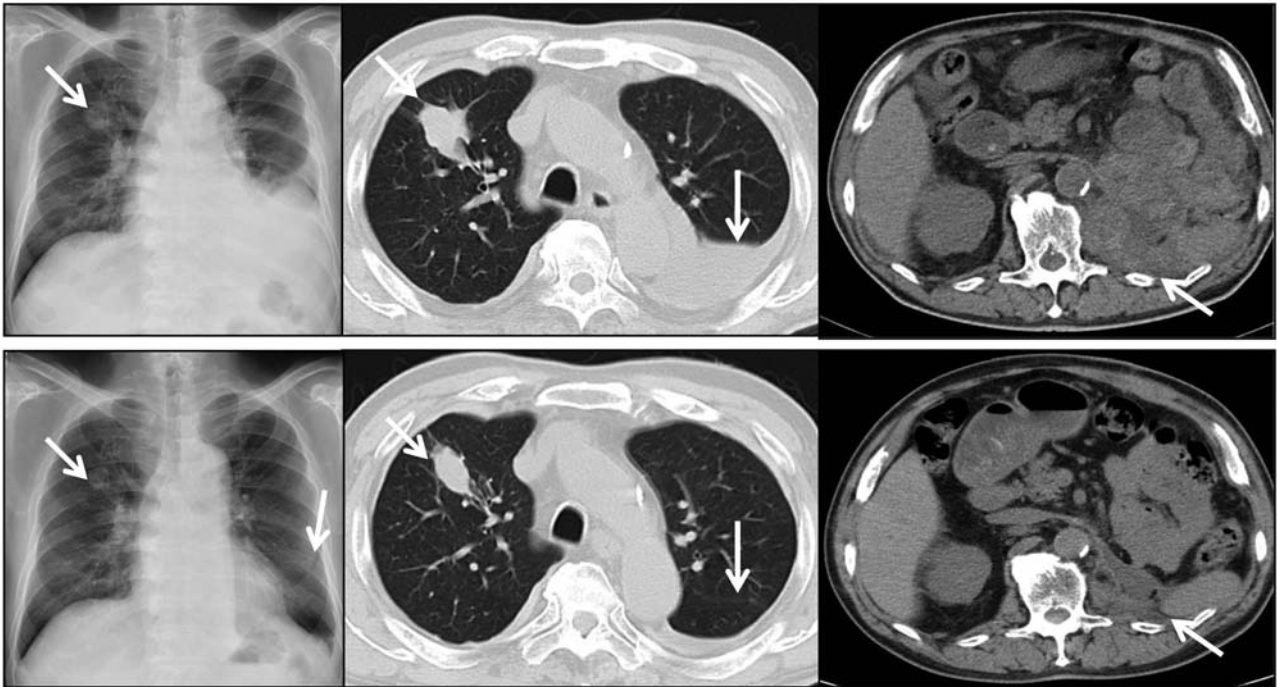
Chest X-ray and computed tomographic scan showing a partial response of both pleuropulmonary and locoregional lesions (arrows) after only two weeks of temsilorimus treatment. Upper: Pre-treatment, Lower: post-treatment.
